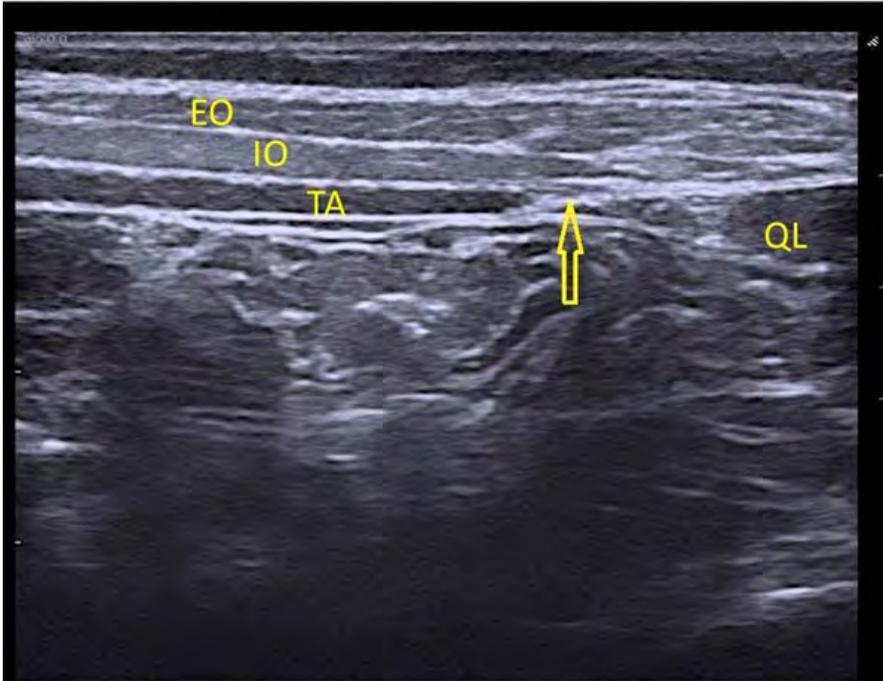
Ultrasound picture showing the abdominal wall muscles and the local anesthetic injection site (arrow). EO=External Oblique; IO=internal oblique; TA=transversus abdominis; QL=quadratus lumborum.
